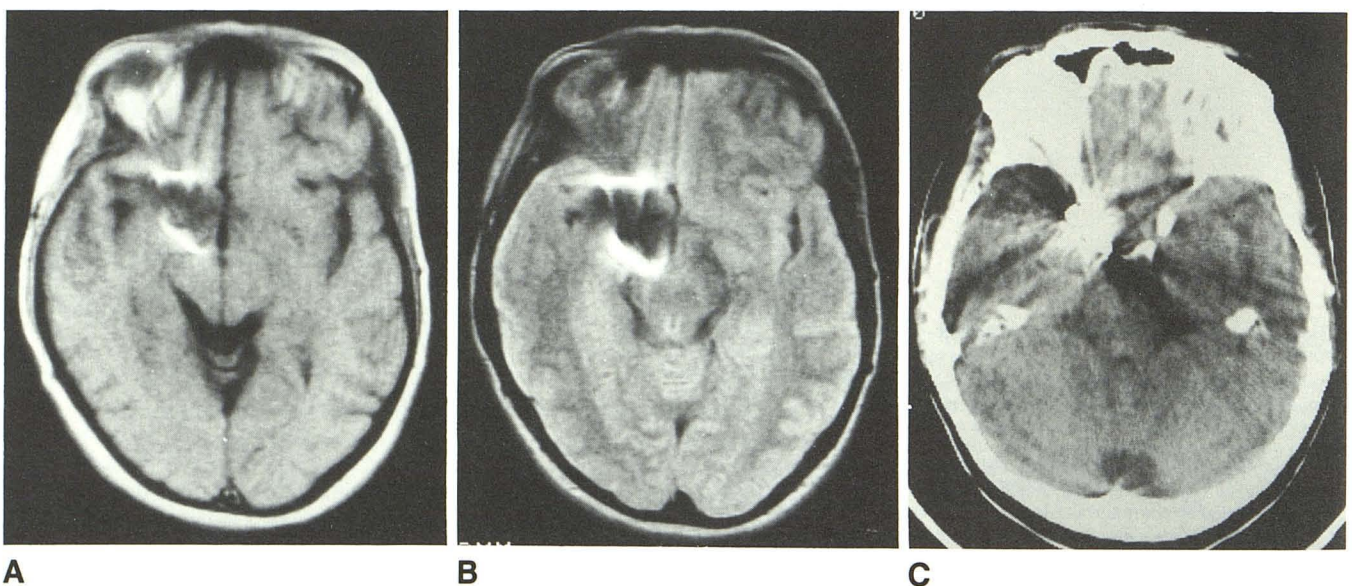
Short TR/TE (A), long TR/TE (B), and CT (C) images in patient with Yasargil aneurysm clip (18 mm, 337 mg). Note rim of increased signal in frequency-encoding (sagittal) direction. Except for artifact, findings are normal in region of surgery.
